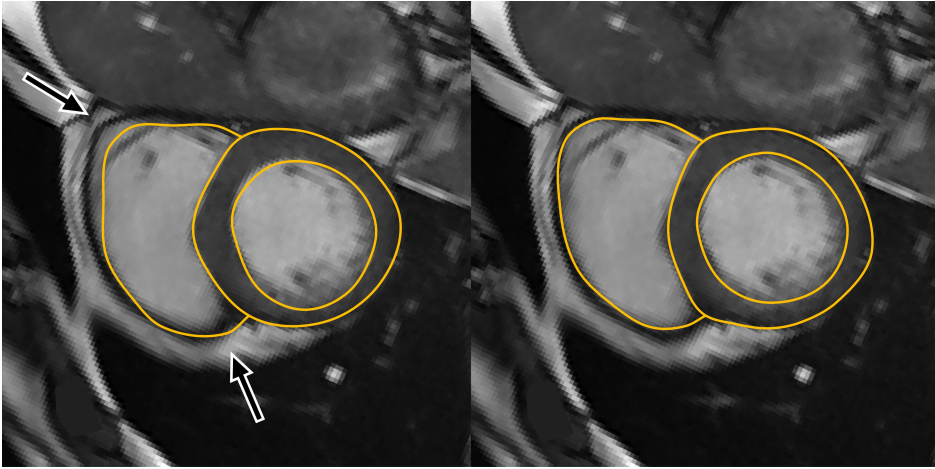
Example of the improvement in segmentation accuracy obtained with the combined model. The left image shows the MR-model segmentation, and the arrows indicate the most prominent areas of error. The right image is the MR-CT model.
